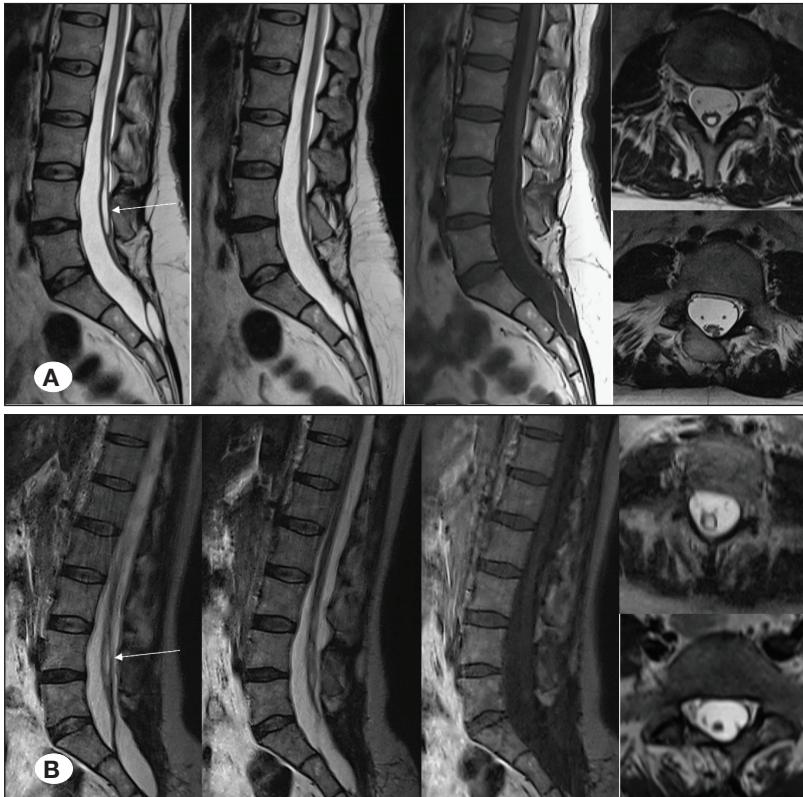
A) A 46 year-old female patient was operated 3 times for tethered cord. Complaints of pain, numbness and frequent urination in the lower back and legs. No significant loss of strength. T2W and T1W sagittal, and T2W axial MRI show that the spinal cord ends L5-S1 levels. B) Postoperative 3rd month: She describes mild low back pain. His numbness continues although it has decreased. There was no change in frequent urination. T2W and T1W sagittal, and T2W axial MRI show that the spinal cord untethered and syringomyelia decreases. However, there is a new band starting from the conus and extending to the anterior surface of the canal.
